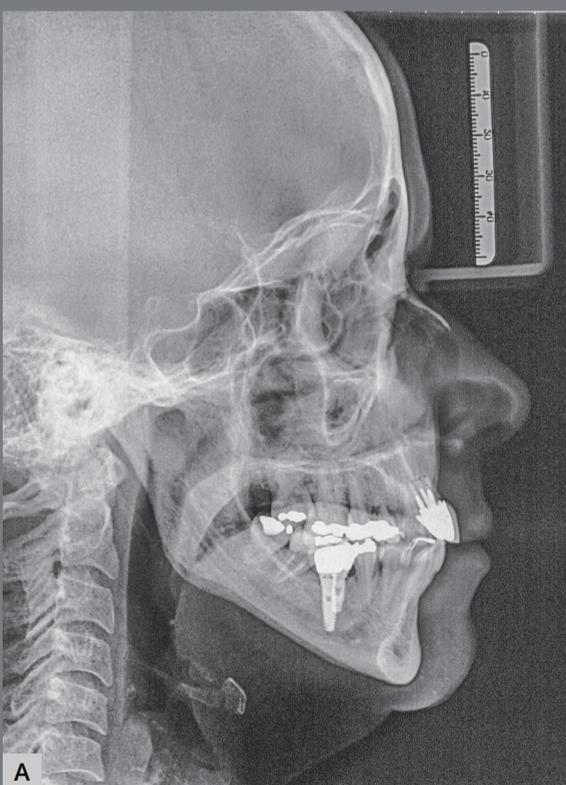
Cephalometric radiograph (A) and cephalometric tracing (B) 8 years after the end of treatment.
